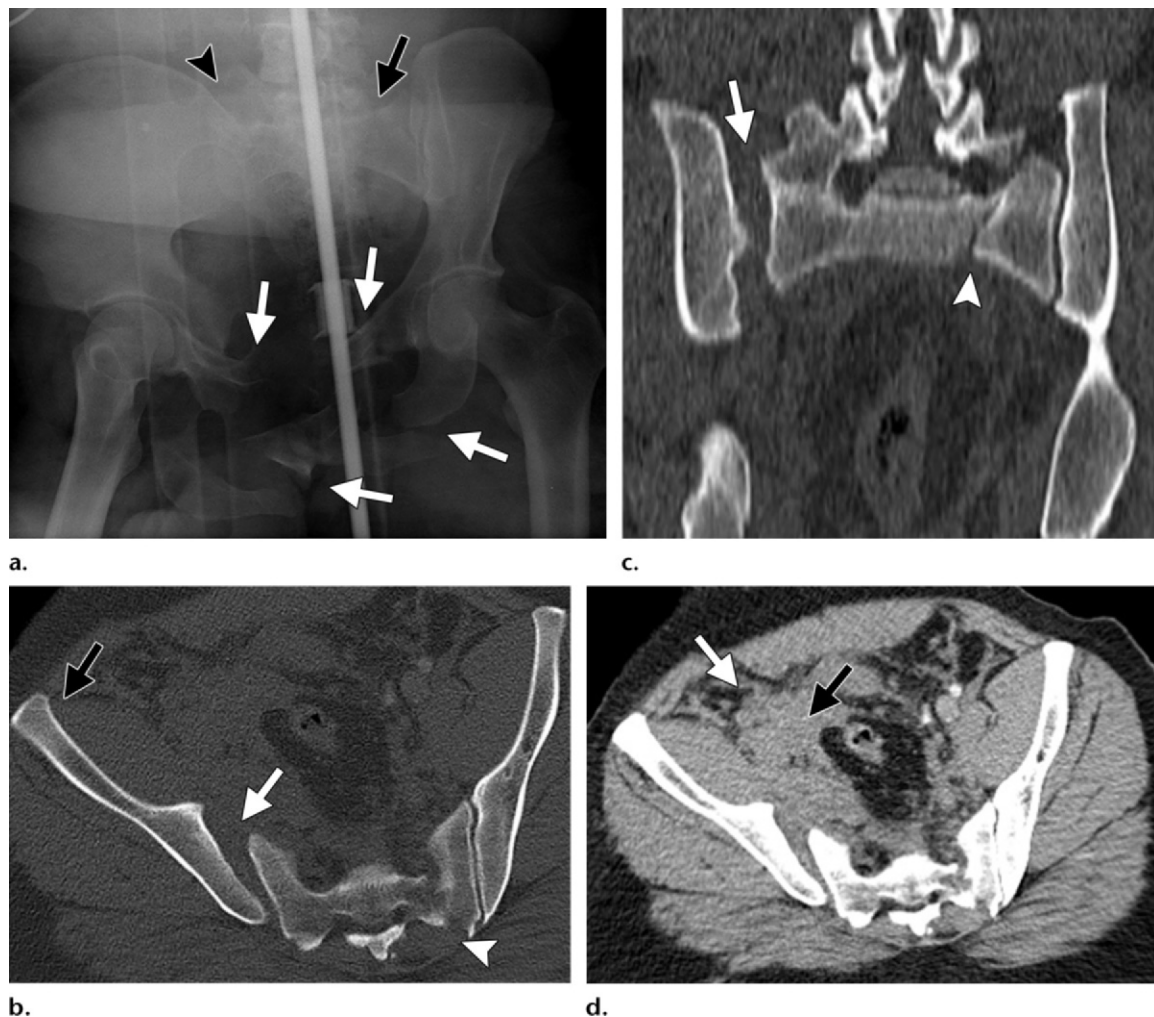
Lateral compression type 3 injury in a 28-year-old male pedestrian who was struck by a truck moving at high speed. (a) AP radiograph of the pelvis shows a medialized left hemipelvis, fractures of the bilateral superior and inferior pubic rami (white arrows), and a compression fracture through the left sacrum (black arrow), a finding consistent with a lateral compression injury. Gross widening of the contralateral right SI joint (arrowhead) with external rotation of the right iliac wing is also seen, findings indicative of a “wind-swept pelvis” injury. (b, c) Axial (b) and coronal (c) CT images show an impaction fracture of the left sacrum (arrowhead) secondary to a compression force and external rotation on the right (black arrow in b), with right SI joint dissociation (white arrow) and relative anterior displacement of the right iliac bone, findings indicative of an AP compression type 3 injury. (d) Axial CT image obtained with soft-tissue window settings shows a large right-sided extraperitoneal hematoma (black arrow) and a lack of opacification in the right internal and external iliac arteries (white arrow). The patient was found to have avulsion of both vessels and underwent emergent laparotomy for hemorrhage control and right hemipelvectomy.
